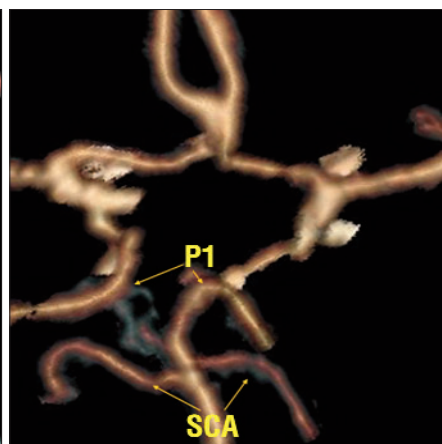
3D CT angiography reconstruction: right P1 segment fenestration. P1 - precommunicating segment of the PCA, SCA - superior cerebellar artery
